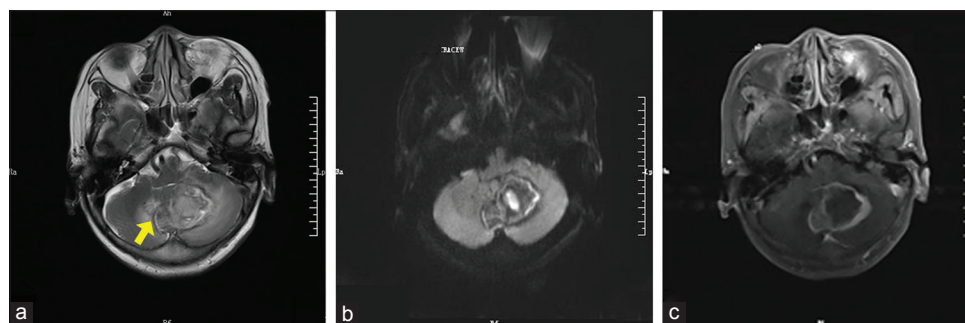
Representative imaging findings of a 63-year-old woman (patient 2): (a) T2-weighted showed the lesion was located in the left cerebellum and cerebellar vermis (arrow). There was a hyperintensity mixed with hypointensity, which heterogeneous signal on T2 weighted. There was mild edema surrounding the mass. (b) The lesion is diffusion-limited on the DWI scan. (c) The lesion was heterogeneously enhanced, following administration of the contrast agent. DWI: Diffusion-weighted imaging.
